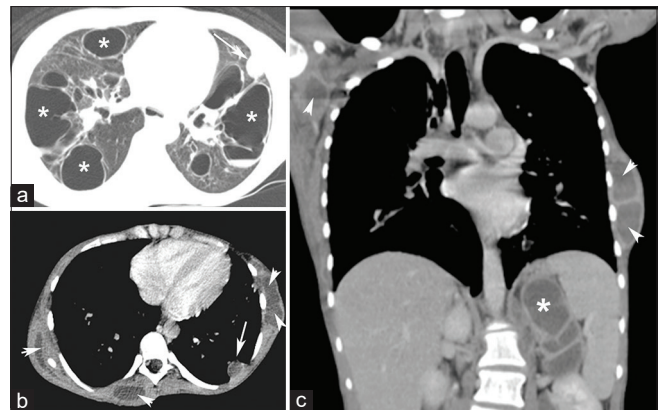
(a) Computed tomography of the chest showing thin-walled pneumatoceles (asterisks) with air–fluid level and septae, associated with bronchiectasis and a peripheral nodule. The mediastinal window setting (b) demonstrates a peripheral nodular lung abscess (arrowheads) and intramuscular abscesses on the chest wall (arrows). Coronal reconstruction (c) reveals numerous intramuscular collections and intra-abdominal abscesses, most with peripheral contrast enhancement, on the left psoas muscle and in the left adrenal region (white asterisks). Note also the abscesses on the chest wall (arrows)
